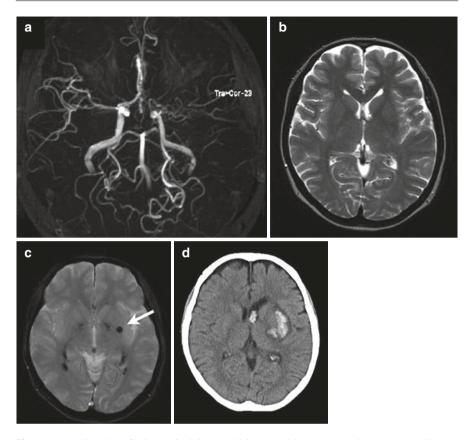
Radiological findings of a 26-year-old female with asymptomatic moyamoya disease. On MR angiography (a), the supraclinoid portion of the internal carotid artery and its main branches are severely stenotic on the left sides, which is associated with typical moyamoya vessels. T2-weighted images (b) show no parenchymal lesions, but T2*-weighted images (c) clearly demonstrate the microbleed in the left putamen (arrow). Plain CT scan (d) taken 4 years later shows intracerebral hemorrhage in the left putamen
